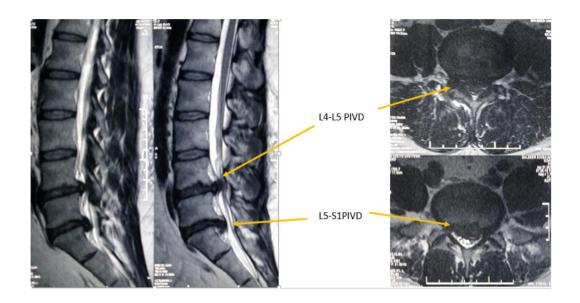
The above MRI revealed disc herniation at the L4-L5 and L5-S1 levels.²³
